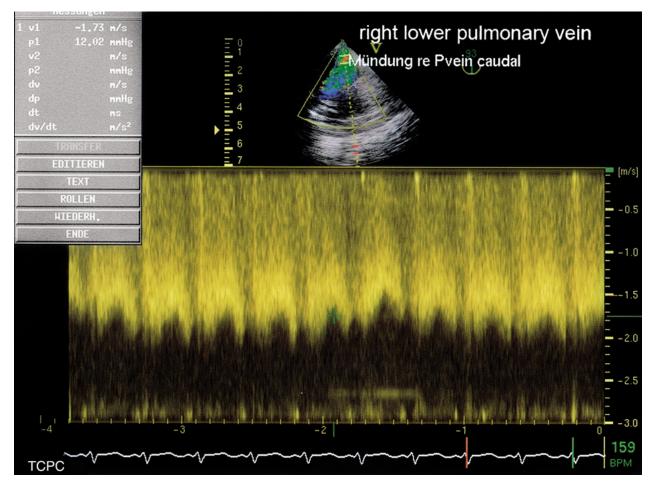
Doppler flow signal demonstrating a significant gradient in the right pulmonary veins.
